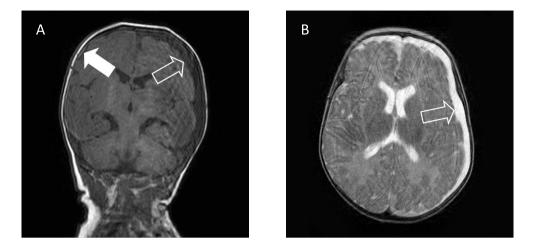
Case 5. Coronal T1-weighted MR image of a 5-month-old boy who fell from a carry cot. Information not available to the participating radiologists: The boy was brought to the emergency department after a trauma with immediate clinical signs. He was pale, weak and unresponsive and was admitted to the pediatric ward. The clinical history later changed into an abusive incident. The MR scan was performed after 2 days. MRI, hampered by motion artefacts, shows a left sided hypo-intense SDH (open arrow). A thin right sided hyper-intense SDH is seen on the right side (arrow). Figure 5b. Axial T2-weighted MR image of the same boy shows a hyper-intense SDH along the left convexity (open arrow). The thin right sided SDH is not visible on this image.
